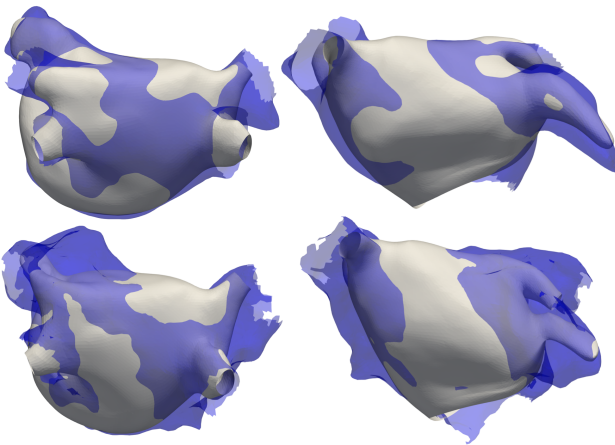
Top row: Roof and anterior view of the SSM instance (grey) best fitting to the target MRI segmentation (semi-transparent blue). Bottom row: Roof and anterior view of the SSM instance (grey) best fitting to the target electroanatomical map (semi-transparent blue).
